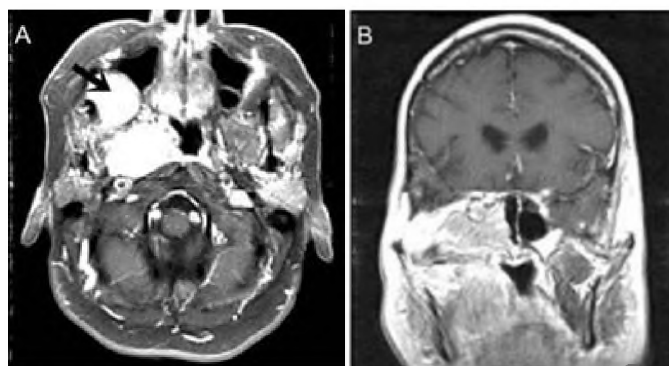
Preoperative axial (A) and coronal (B) magnetic resonance imaging showing a meningioma originally located in right middle fossa that has invaded into infratemporal fossa and maxillary sinus (indicated by arrow).
